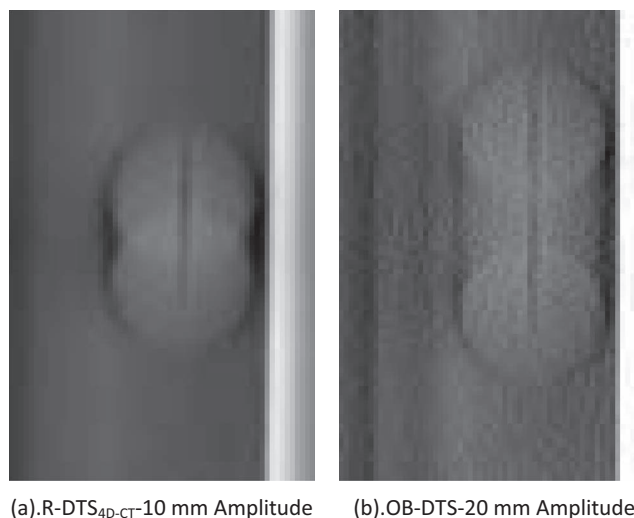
Comparison between the shapes of ITVs of (a) R-DTS_{4D-CT} and (b) OB-DTS with 10 mm amplitude variation.
